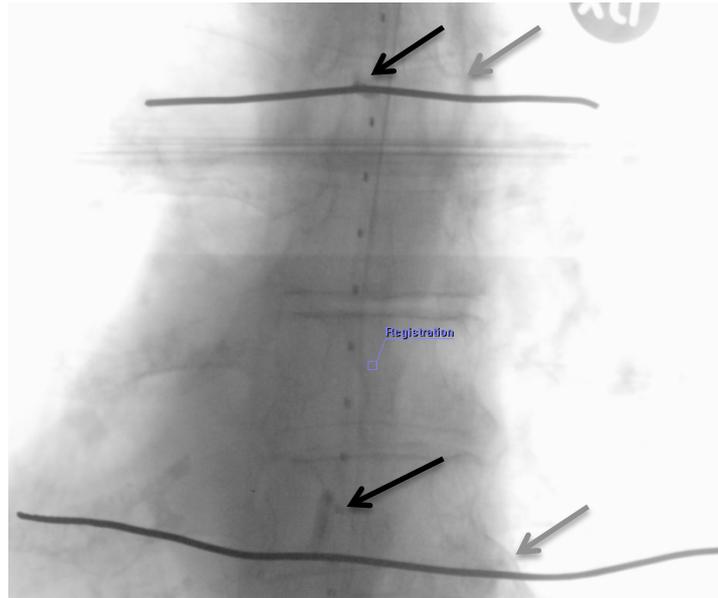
X-ray image used for treatment planning, visualising clips that marks the distal and proximal borders of the tumour (black arrows) and a marker wire that presents the dwell positions of the source. External lead skin markers are also visualised in the image (grey arrows).
